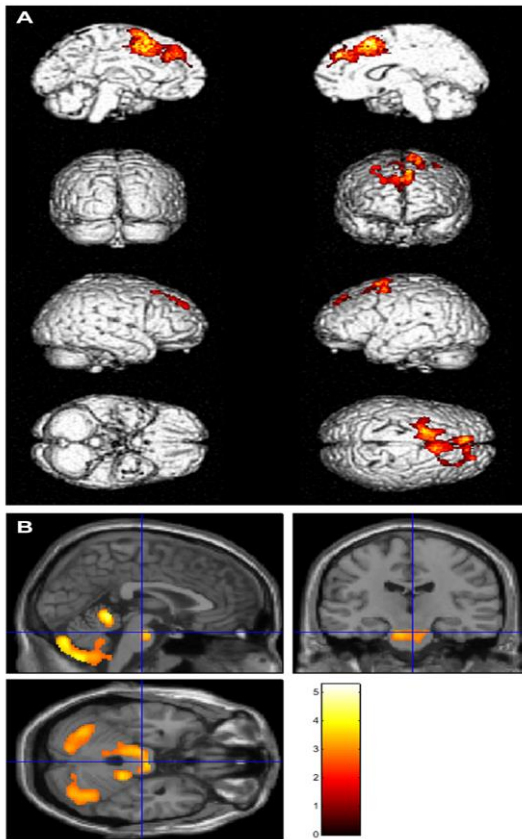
A. Clusters of relative hypometabolism in patients with FrsBe apathy “before-after” gap ≥ 22 as compared to patients with “before-after” gap < 22 are projected on brain surface. B. Clusters of relative hypermetabolism in patients with FrsBe apathy “before-after” gap ≥ 22 as compared to patients with “before-after” gap < 22 are represented on a brain MRI template.
